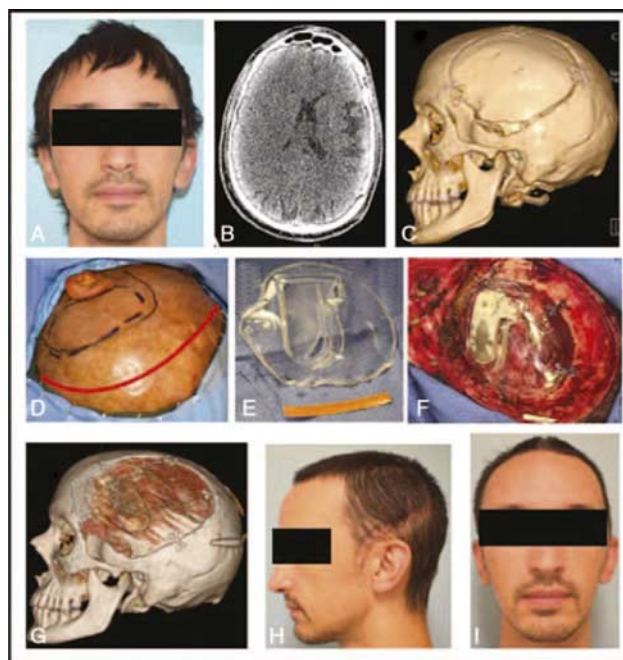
Photographs and CT scan images from a patient who underwent cranioplasty with a customized clear PMMA implant with embedded Responsive Neurostimulator (RNS) system. This is a 28-year-old male with a history of drug resistant epilepsy for which he previously underwent resection of the seizure focus. He continued to have seizures; however, due to the residual foci being in eloquent areas of the brain, he was not a candidate for further resective therapy. He was evaluated by a multidisciplinary epilepsy treatment team and determined to be a candidate for RNS. After placement of the device, he was noted to have a 70% reduction in seizure frequency 3 months after the operation. (A-C) Preoperative photograph, representative horizontal CT scan showing area of previous left temporal lobe resection, and 3D CT scan showing prior craniotomy site, respectively. (D-F) Intraoperative photographs. (D) shows preoperative markings. Note the craniotomy site outlined with the dashed lines, the previous scar outlined by the solid black line, and the placement of the new incision demonstrated by the red line. A new incision was used to prevent placement of the incision directly over the cranial implant. (E-F) shows the custom implant on the back table, and after placement with the embedded RNS device, prior to scalp closure. (G) Postoperative 3D-CT scan showing the implant with embedded RNS device. (H-I) Early postoperative photographs of the patient showing healing incision, with excellent symmetry and cranial contour. 3D-CT, three-dimensional computed tomography.
